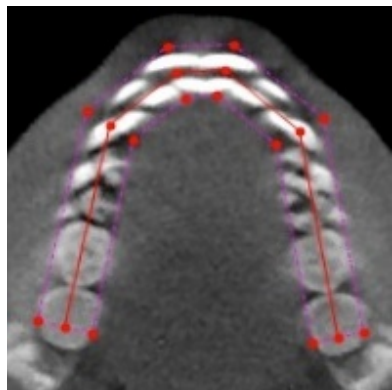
Cut Line: CBCT Simple Pano - Dolphin
